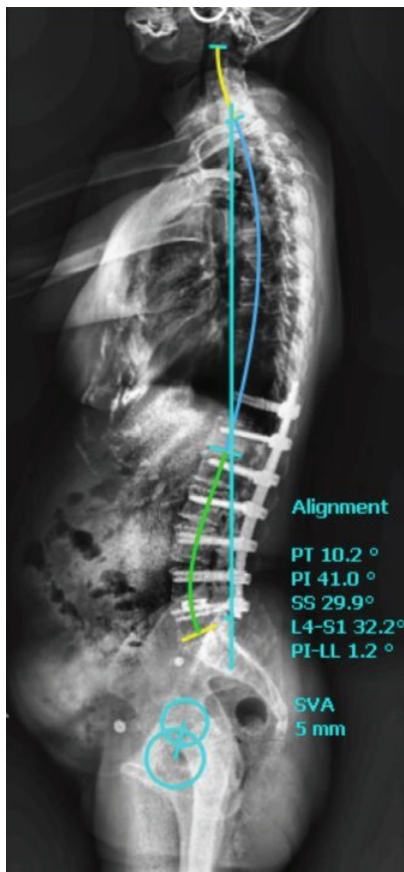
Postoperative lateral spine radiograph of patients treated with long level fusion surgery
